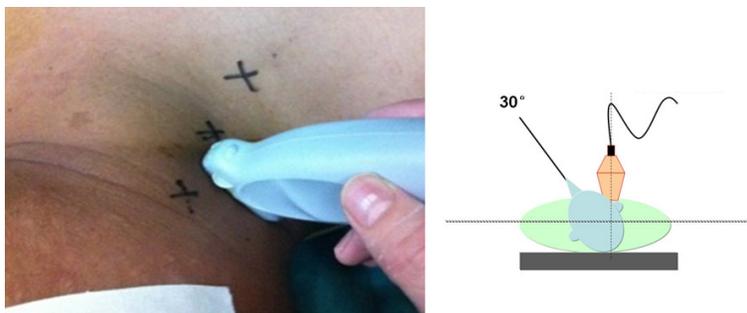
The short edge of an ultrasonic probe was used to measure the inner diameter of vessels and the overlapping distance at three points (high, medium and low levels) when the patient tilted their head to the left at 30°.
